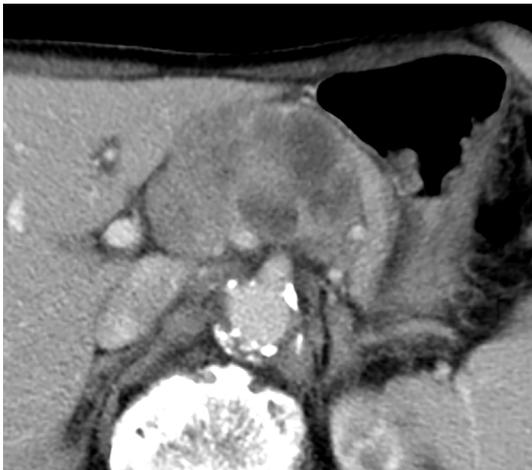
Preoperative abdominal contrast-enhanced computed tomography shows a hypovascular tumor 6 cm in diameter with a cystic or necrotic component in the body of the pancreas.
